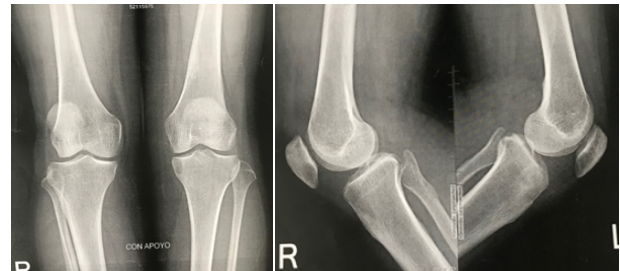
Anteroposterior and lateral knee radiographs showing a lytic lesion at the medial level of the proximal epiphysis of the left tibia.
